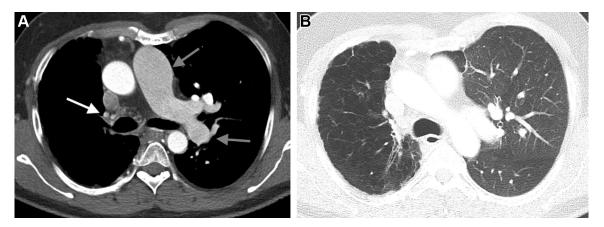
A, Axial contrast-enhanced CT image on mediastinal windows in a 35-y-old man with congenital proximal interruption of the right pulmonary artery showing complete absence of the right pulmonary artery (PA), dilatation of the main PA and left PA (arrows), and bronchial artery collaterals at the right hilum (arrow). B, Axial CT image on lung windows in the same patient showing decreased volume and hyperlucency in the right lung.
